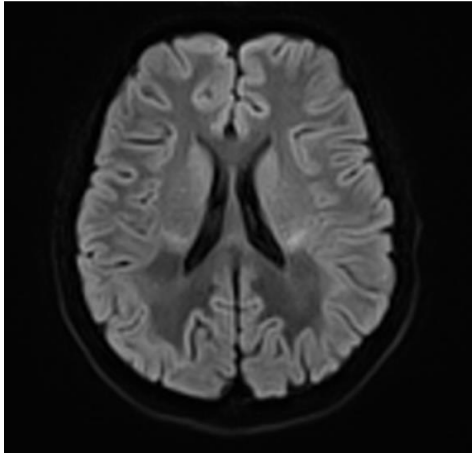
MRI brain of a boy with Addison's disease
